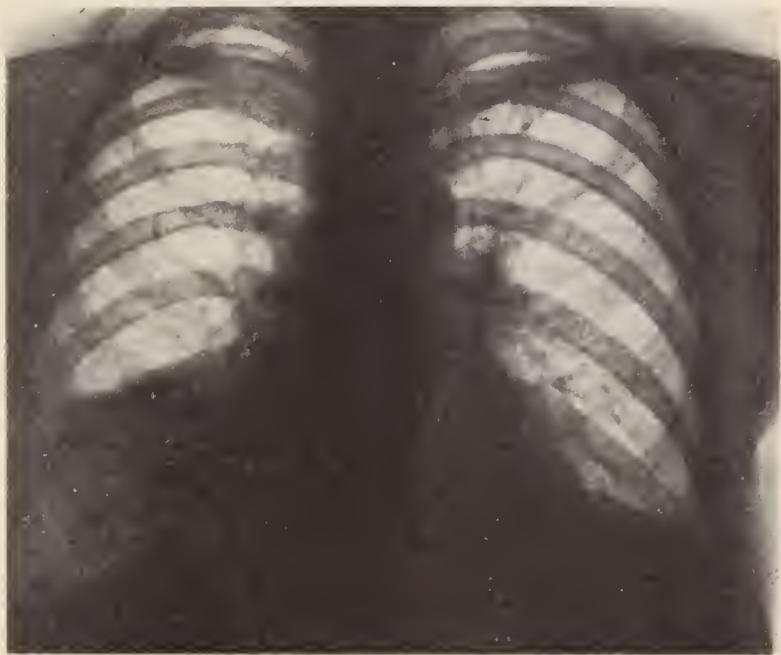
Roentgenogram taken December 17, 1936 showing consolidation of the right middle lobe. There is no evidence of abscess of the left upper lobe.
